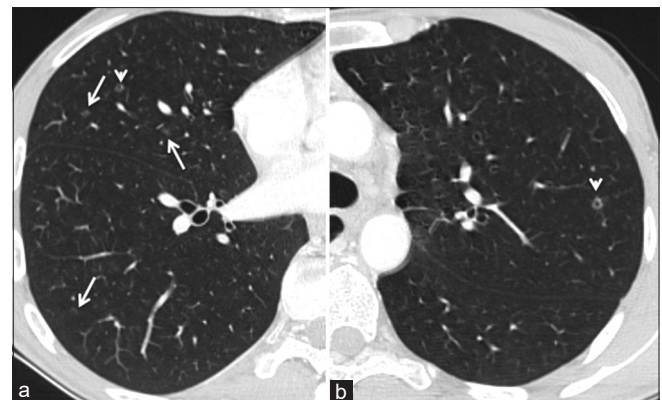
(a and b) Chest CT images with multiple cysts (arrowhead) and solid bilateral irregular micronodules (arrows), predominantly in middle-to-upper lung lobes, but present also in lower lobes, adjacent to bronchus, surrounded by normal lung parenchyma
